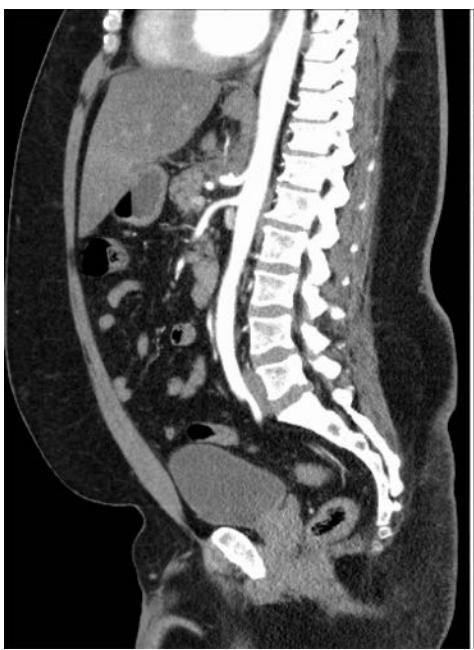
Patient KS postoperative CT abd/pel showing 3-month follow-up with resolution of celiac compression and consistent with mild clinical improvement.
